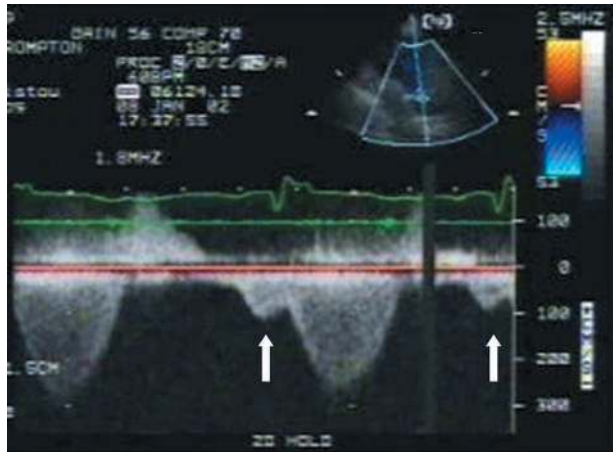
Continuous wave Doppler tracing of the RVOT of a patient with repaired tetralogy of Fallot and severe pulmonary regurgitation. There is residual pulmonary valve stenosis. The pulmonary regurgitation signal ends well before the next systolic signal, which suggests severe pulmonary regurgitation or the existence of a restrictive RV with high RV diastolic pressures, or both. There is a late diastolic signal of forward flow through the pulmonary valve (white arrows), suggesting the existence of a restrictive RV.
